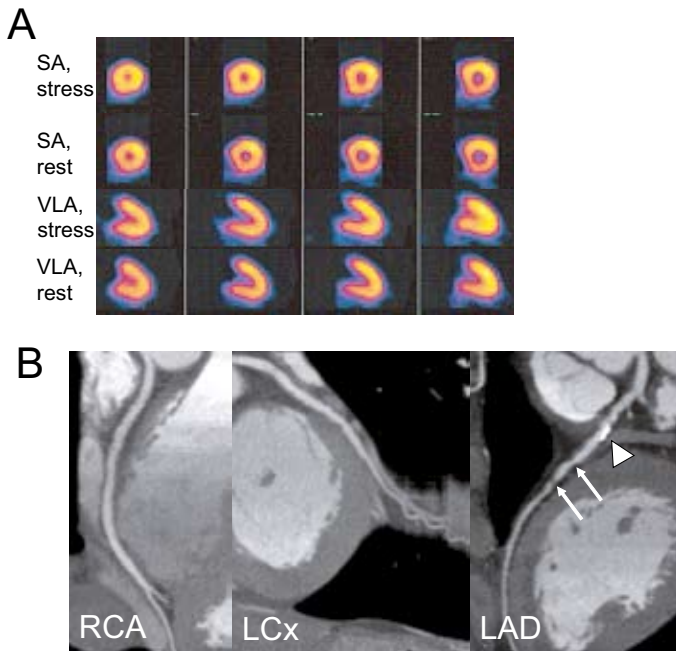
Non-invasive imaging in a 54-year old man with suspected CAD. SPECT perfusion imaging demonstrated normal myocardial perfusion in all territories (Panel A). MSCT coronary angiography was also performed (Panel B). From the left to the right, curved multiplanar reconstructions are shown of the right coronary artery (RCA), left circumflex (LCx) and left anterior descending coronary artery (LAD). Only minor wall irregularities were observed in the RCA and LCx. In the LAD however, a proximal extensive calcified lesion (arrow head) and various non-calcified plaques (arrows) were observed.
